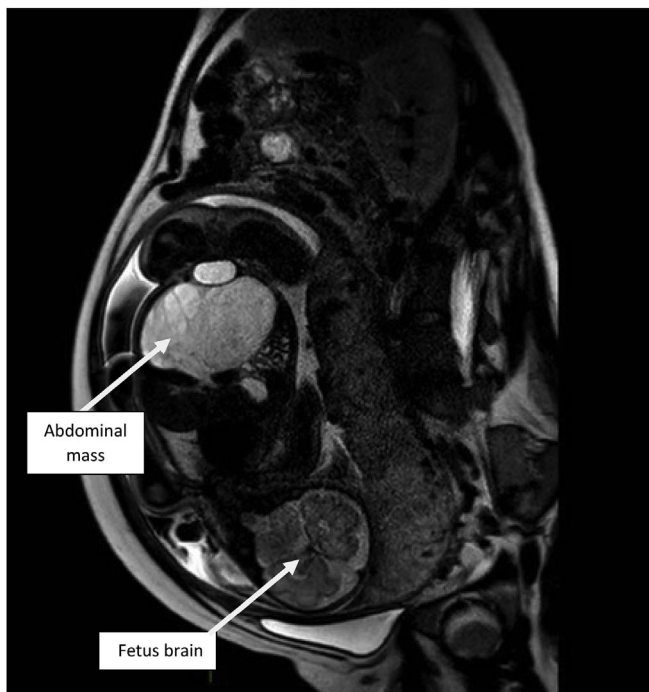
Fetal MRI Images demonstrating mesenchymal hamartoma.
